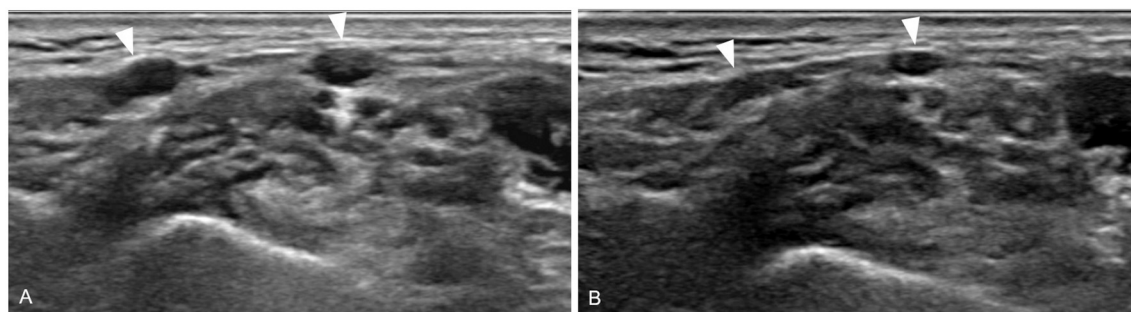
Right supraclavicular lymph nodes that developed one day after the second dose of Pfizer–BioNTech COVID-19 vaccine in the right arm. (A) Ultrasonography performed on the right supraclavicular region four days after the second dose of vaccination demonstrated several small (the largest measuring 0.5×0.2 cm) lymph nodes (marked arrowheads) without cortical thickening and with preserved fatty hilum. (B) One-week follow-up sonography showed decreased size of the nodes.
